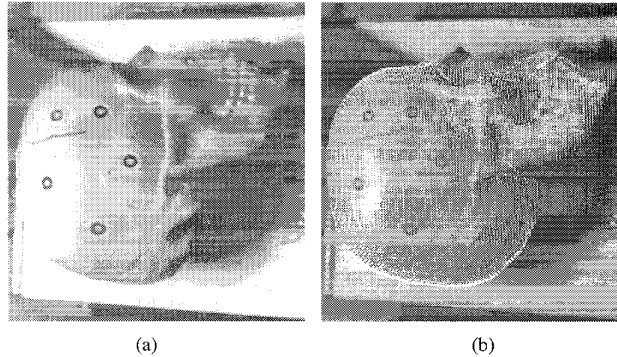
Example of (a) video image, and (b) the overlay of a registered 3-D (CT) model of an object with the real object in that image (figures courtesy of J. P. Mellor).
